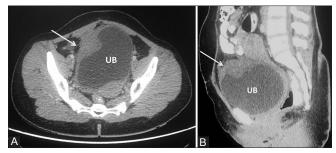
(A and B): Contrast-enhanced CT scan reconstructions in axial (A) and sagittal (B) planes, showing ill-defined, heterogeneous, mildly enhancing mass in the right adnexa, invading into the dome and right anterolateral wall of the urinary bladder (arrows), with surrounding fat stranding. UB = Urinary bladder
